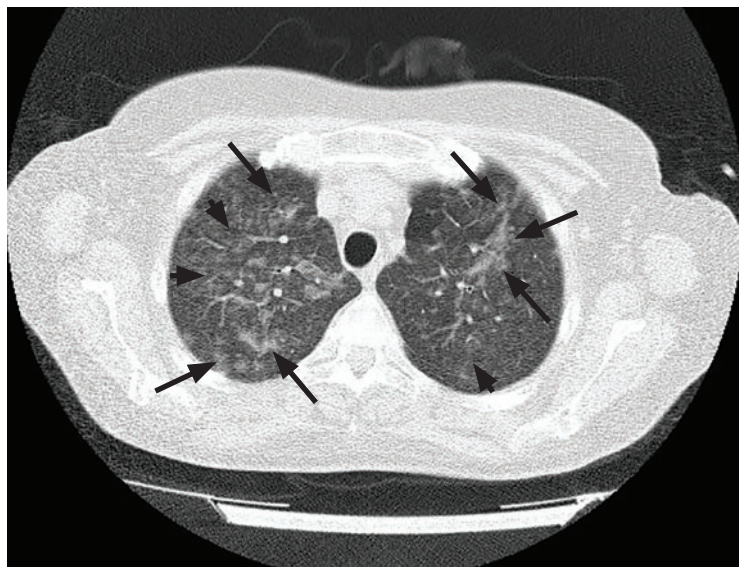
Computed tomography of the lungs revealed bilateral infiltrates (arrows) and ground-glass opacities (arrowheads) mainly in the upper lobes.
